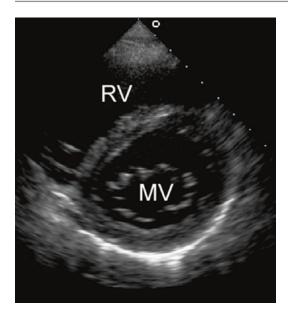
Parasternal short-axis at the mitral valve level during diastole
